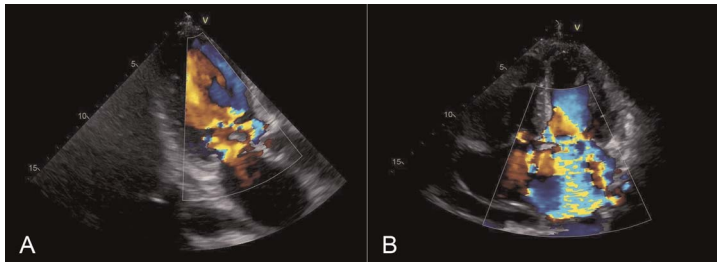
Transthoracic echocardiography images. (A) Severe aortic valve regurgitation. (B) Severe mitral valve regurgitation.
